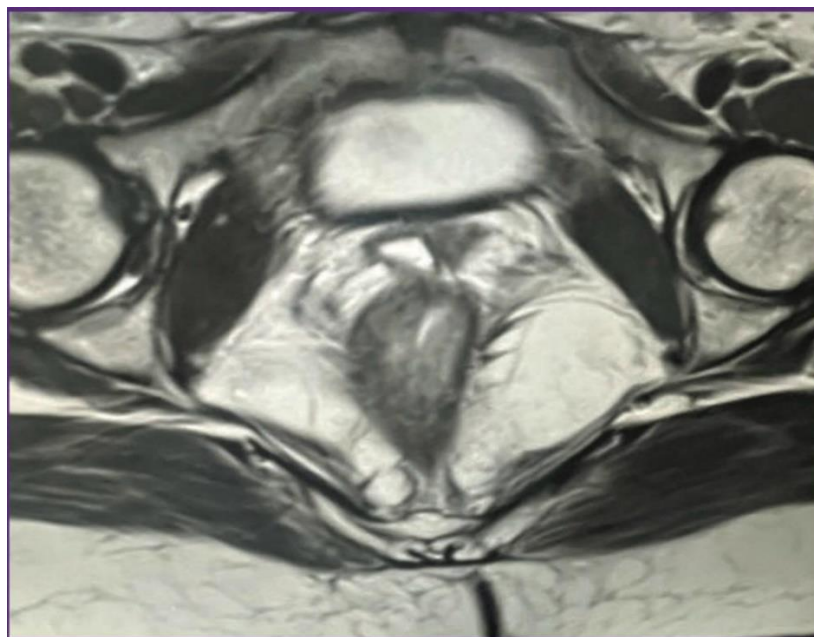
MRI Pelvis shows oblique longitudinal asymmetric complete vaginal septum with dominant right vagina.
